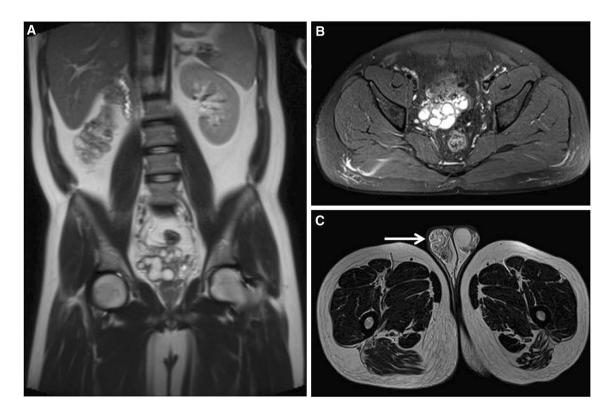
MR images of Zinner's syndrome. T2-weighted coronal image (a) shows absence of the right kidney. Multiple cysts are seen in the right seminal vesicle (b). T2-weighted axial image (c) shows
